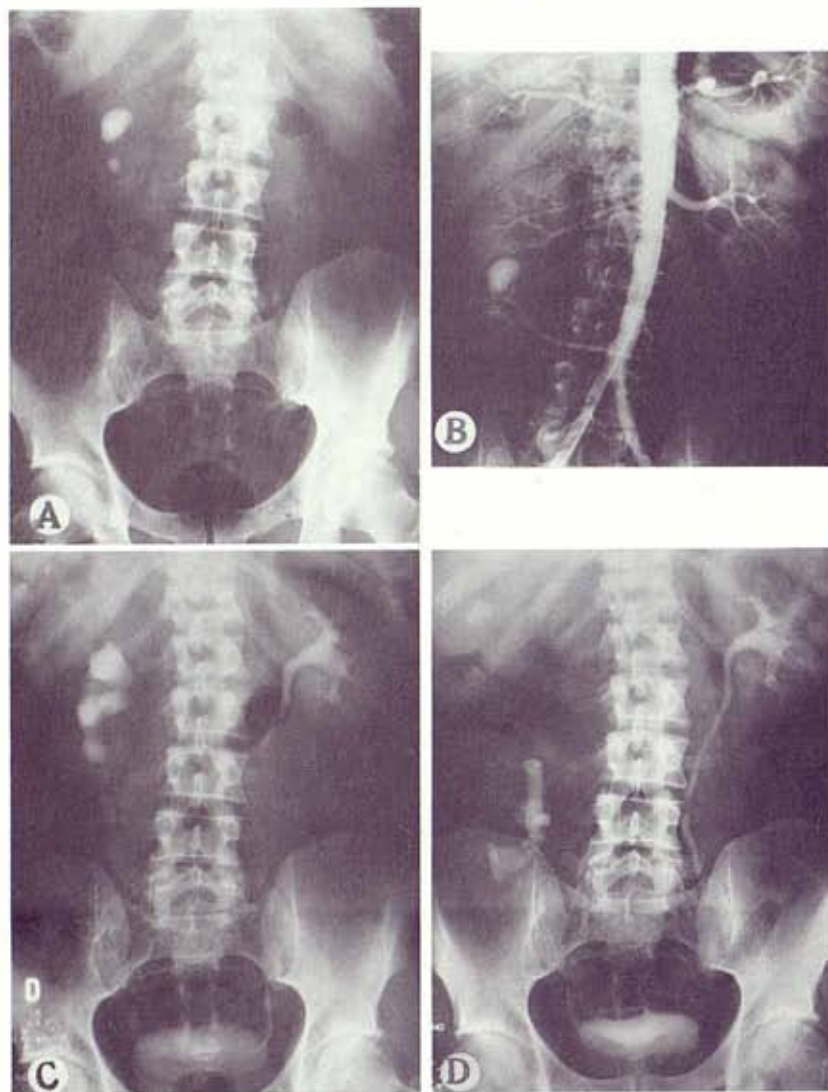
Case 1. A, x-ray reveals relapsing lithiasis in malrotated kidney. B, aortography demonstrates anomalous kidney with 3 arteries. C, preoperative IVP shows dilatation of calices and pelvis of right kidney. D, IVP after nephrectomy, bench surgery and autotransplantation in inverted lumboiliac position.
